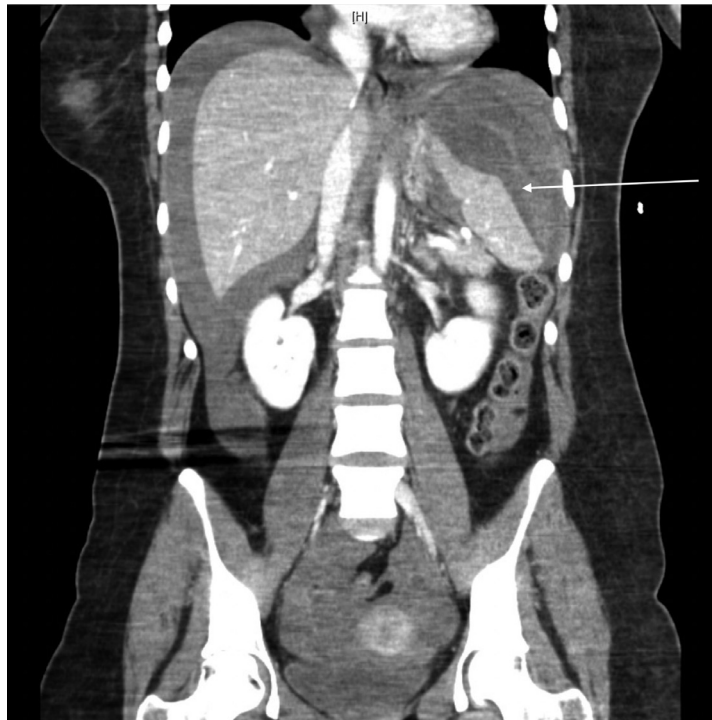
Computed tomography of the abdomen in coronal view, demonstrating a large intraperitoneal peri-splenic haematoma (arrow).
